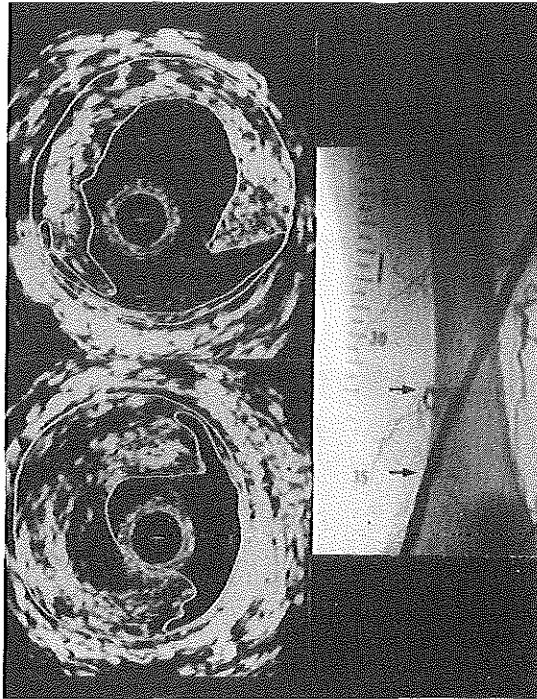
Intravascular ultrasound (IVUS) cross-sections and angiogram obtained from a patient after angiographically defined successful percutaneous transluminal angioplasty (PTA) of the femoropopliteal artery. Note that the presence of a lesion and amount of plaque seen on IVUS is underestimated on the angiogram. The IVUS cross-sections are contour traced off-line facilitating recognition of lumen area (inner contour) and media-bounded area (outer contour). + = catheter; calibration = 1 mm.
